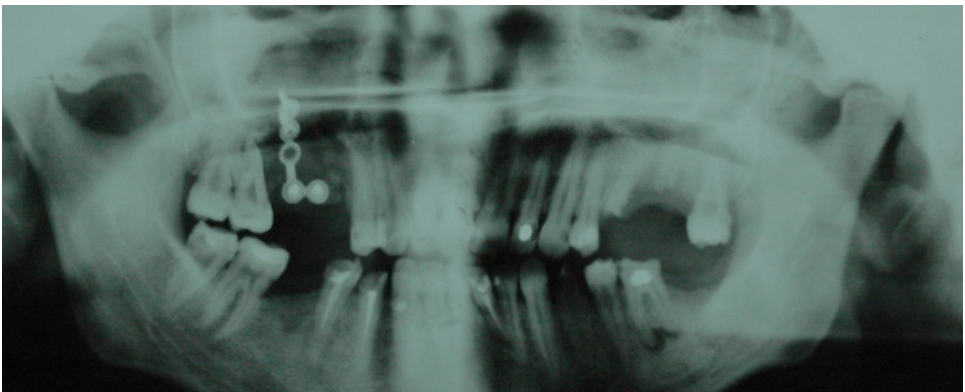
Panoramic radiograph after operation
